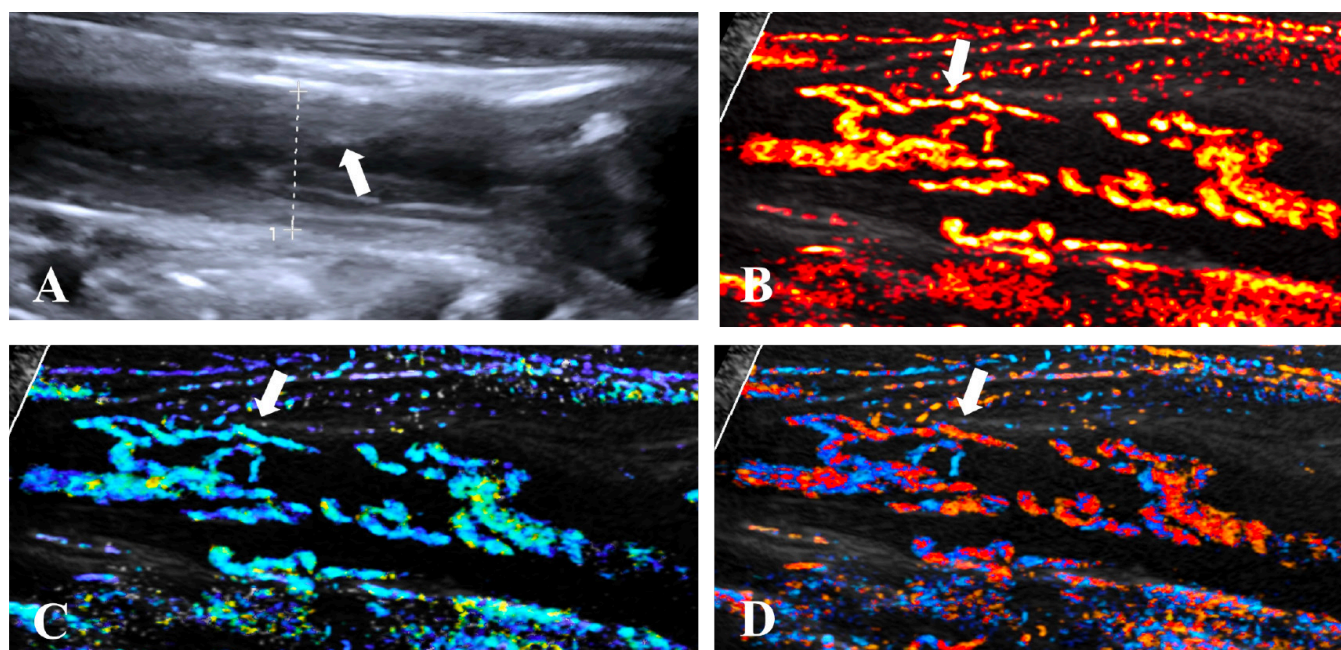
Representative super-resolution ultrasound (SRUS) microvascular imaging of carotid vasa vasorum in Takayasu's arteritis. A: B-mode US demonstrates obvious irregular thickening of carotid artery wall (white arrow). B-D: SRUS microvascular imaging parametric maps reveal vasa vasorum within the thickened arterial wall (white arrows). B: Vessel density map. C: Flow velocity map. D: Flow direction map.
